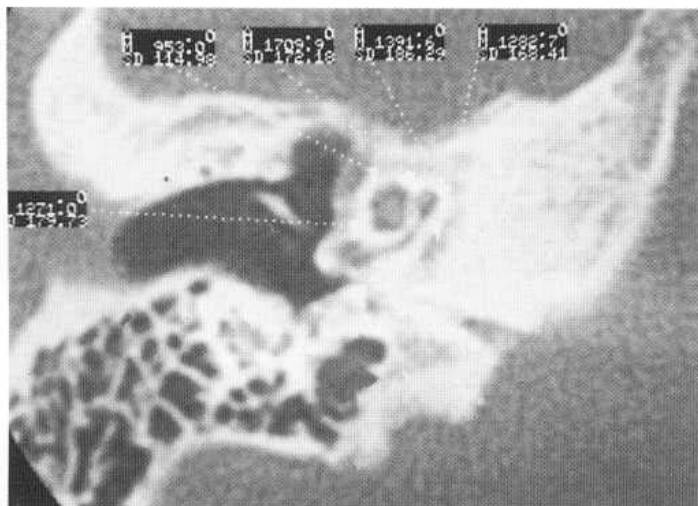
Axial CT with densitometry, showing otospongiosis as a ring of rarefaction around the cochlear coils. The densitometry readings are mostly around 1200 HU. The normal range is 1800-2400 HU.
